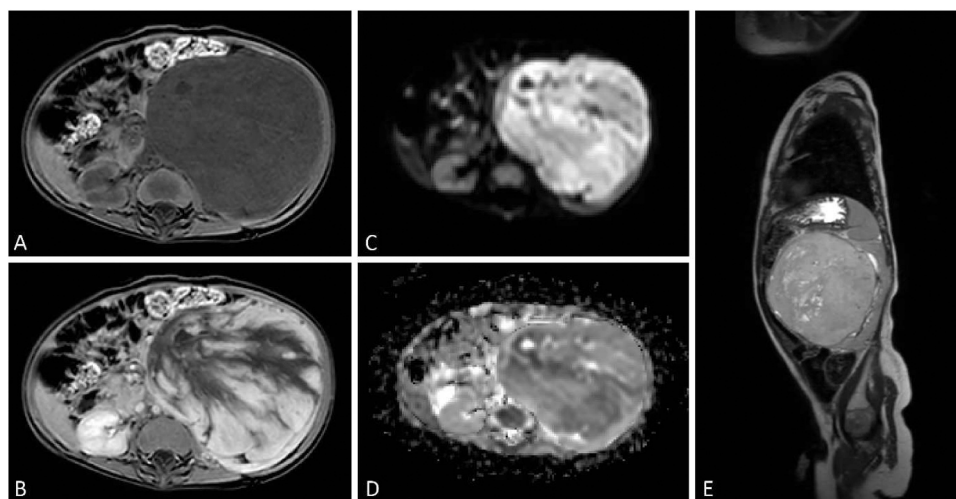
Diagnostic magnetic resonance imaging (MRI) of a 7-month-old male patient with a left-sided clear cell sarcoma of the kidney (CCSK). A 7-month-old male patient presented with a large left-sided renal tumor (419 cc) with well-defined margins and a tumor capsule. On T1-weighted (T1W) imaging (A) the tumor appeared homogeneous and hypo-intense, with a characteristic band-like enhancement pattern on T1W contrast-enhanced imaging (B). Diffusion weighted imaging (DWI) showed limited diffusion restriction based on the b1000- (C) and apparent diffusion coefficient (ADC)-map (D), with a mean ADC of $1.12 \times 10^{-3} \text{ mm}^2/\text{s}$ (range of drawn ROIs $1.10\text{--}1.13 \times 10^{-3} \text{ mm}^2/\text{s}$). On the sagittal T2-weighted (T2W) scan (E), the tumor appeared heterogeneous and hyper-intense, with a few peripheral cysts.
